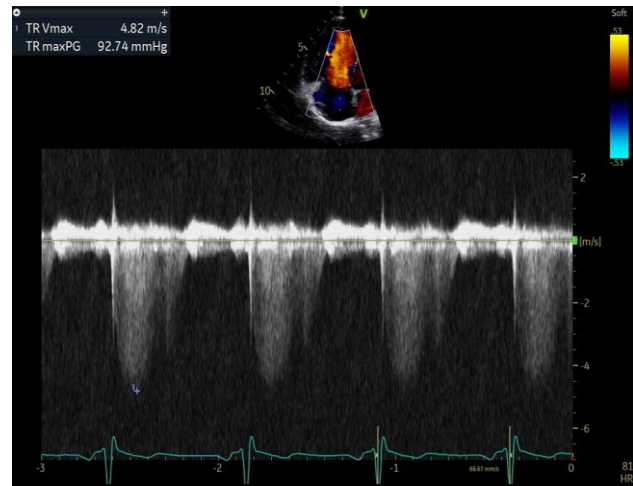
Trans-thoracic echocardiography image with CW Doppler, showing elevated right ventricle systolic pressure measured at 108 mmHg (estimated from peak TR velocity jet + RAp) (Rap: right atrial pressure & TR: tricuspid regurgitation) (reprinted with permission of the patient)
